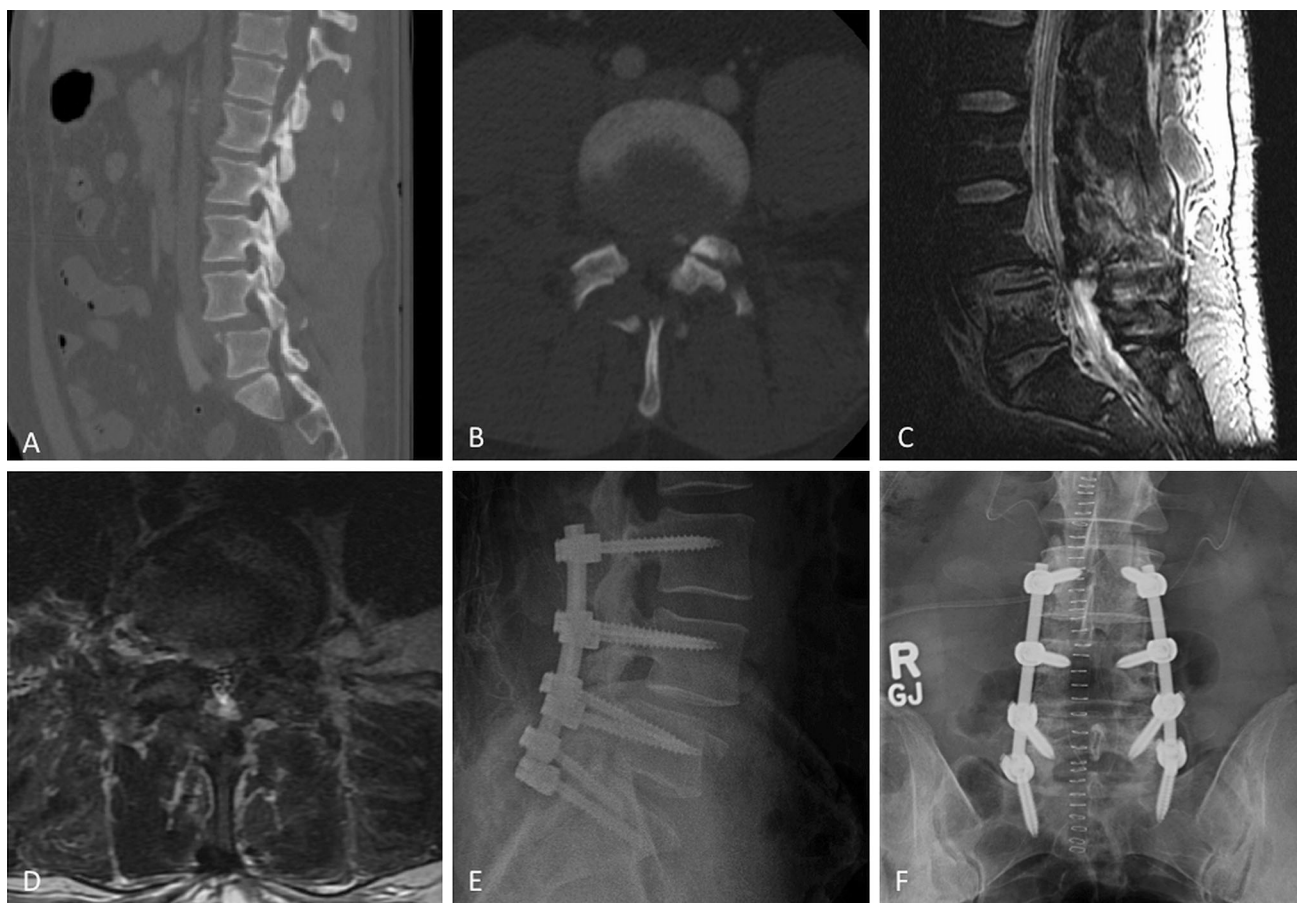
a, b Computed tomography (CT) scan of the lumbar spine showing the locked L4–5 facet joint complex resulting in a Grade 2 anterolisthesis of L4 on L5. There is an associated fracture of the right L5 superior articular facet process. c, d Magnetic resonance (MR) images reveal rupture of the L4–5 disc, and disruption of the anterior and posterior longitudinal ligaments, as well as the ligamentum
